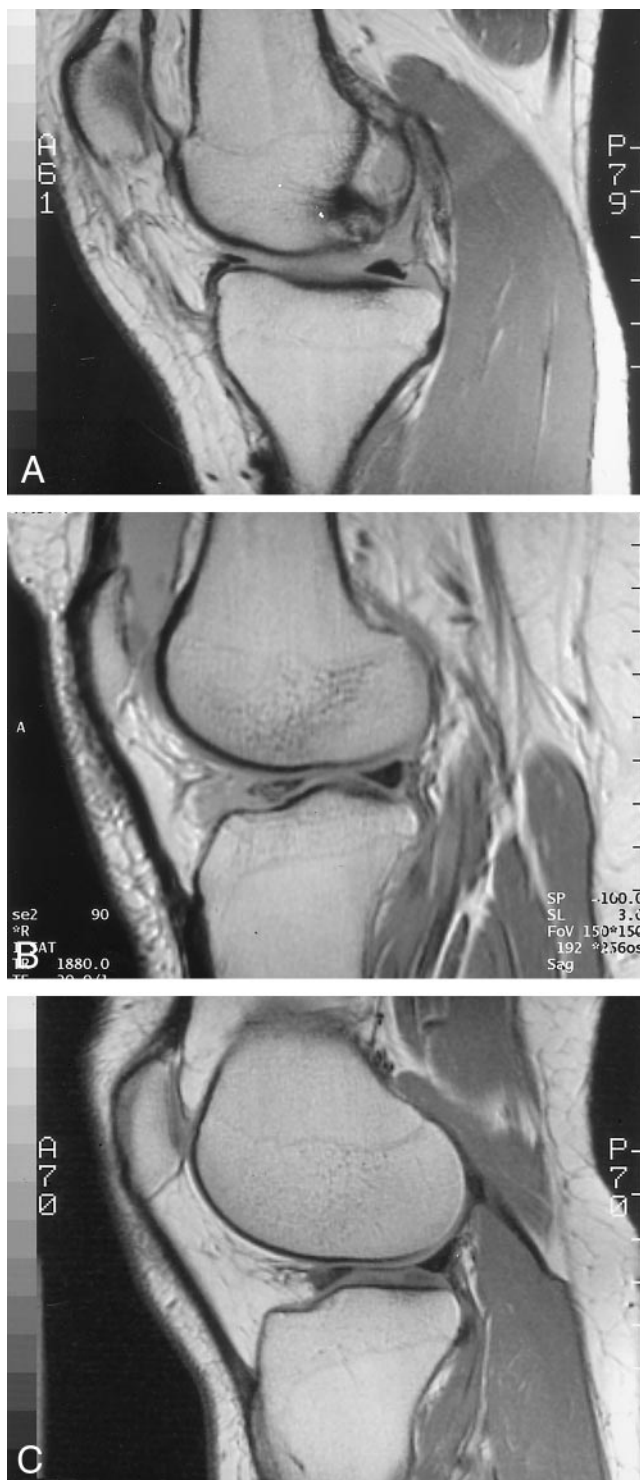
Magnetic resonance imaging scans of knees in which an anterior horn meniscal tear was diagnosed. A, a large anterior horn bucket-handle tear was found during arthroscopic examination (true-positive MRI result). B, an intact meniscus in all zones was found during arthroscopic examination (false-positive MRI result). C, patient was not examined arthroscopically and was completely asymptomatic at the time of the follow-up interview.
